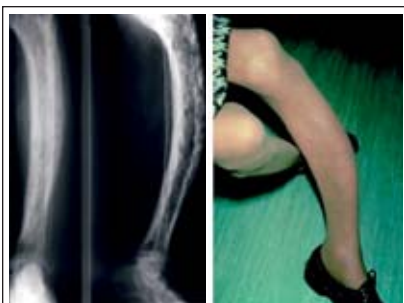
Extreme case of PDB of the tibia (X-rays, courtesy of Ian Maddison)
